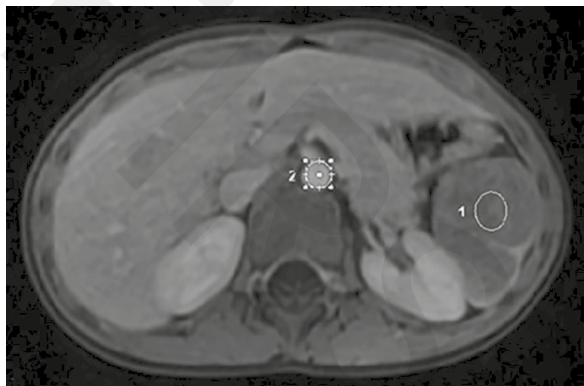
Magnetic resonance imaging of the spleen in the sagittal plane (April 2024), showing the splenic lesion
